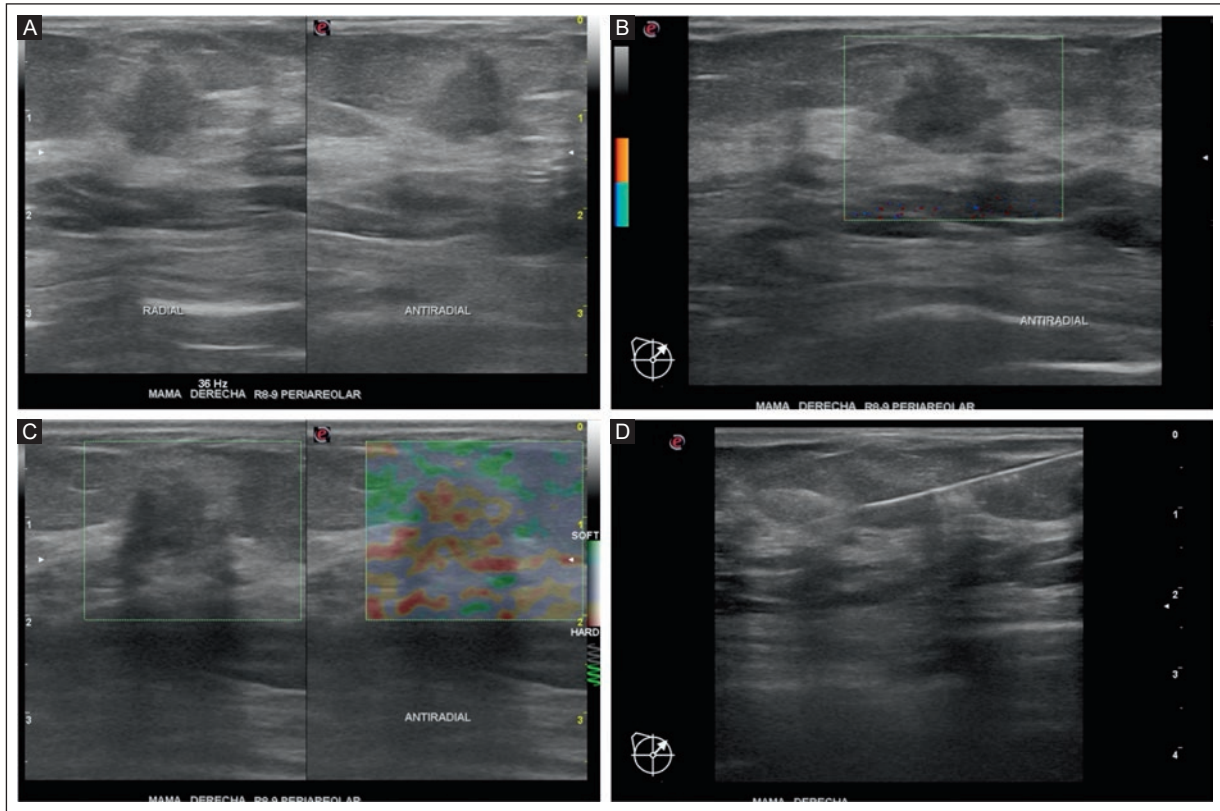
US of a 74-year-old woman with synchronous bilateral breast cancer. A: grayscale US of the right breast in radial and antiradial view shows an irregular hypoechoic mass with parallel orientation and an indistinct margin. B: there is no flow signal on color Doppler US. C: there is intermediate hardness on qualitative elastography. D: a hyperechoic needle is seen in the mass during the biopsy, BI-RADS 5. US: ultrasound.
